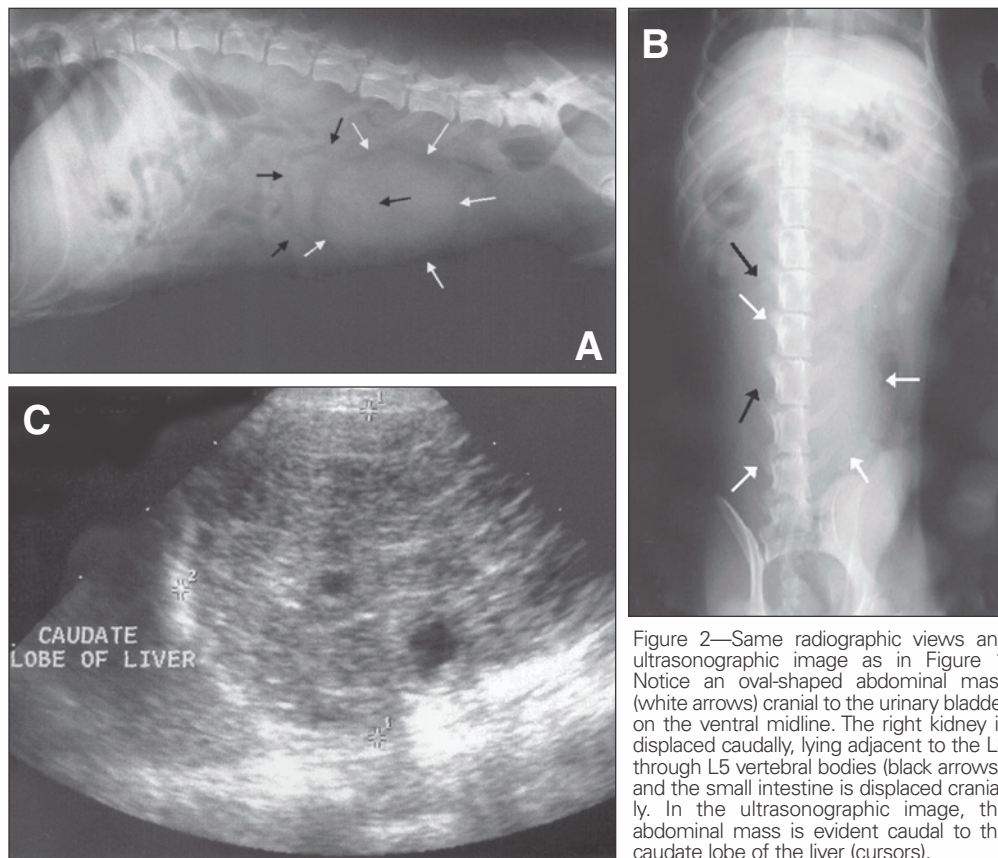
Same radiographic views and ultrasonographic image as in Figure 1. Notice an oval-shaped abdominal mass (white arrows) cranial to the urinary bladder on the ventral midline. The right kidney is displaced caudally, lying adjacent to the L3 through L5 vertebral bodies (black arrows), and the small intestine is displaced cranially. In the ultrasonographic image, the abdominal mass is evident caudal to the caudate lobe of the liver (cursors).
